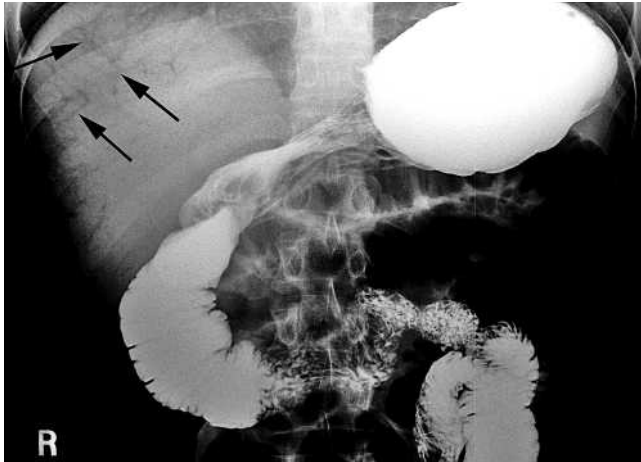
Hepatic portal venous gas (black arrows) seen as radiolucencies extending to the periphery of the liver capsule on plain film following administration of oral barium contrast.
